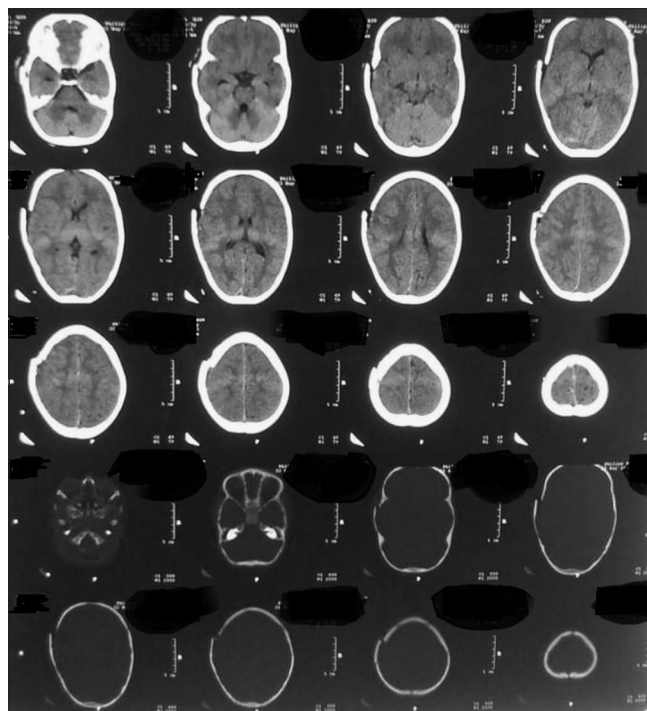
Noncontrast Computed Tomography brain showing elevated fracture of the right Frontal bone
